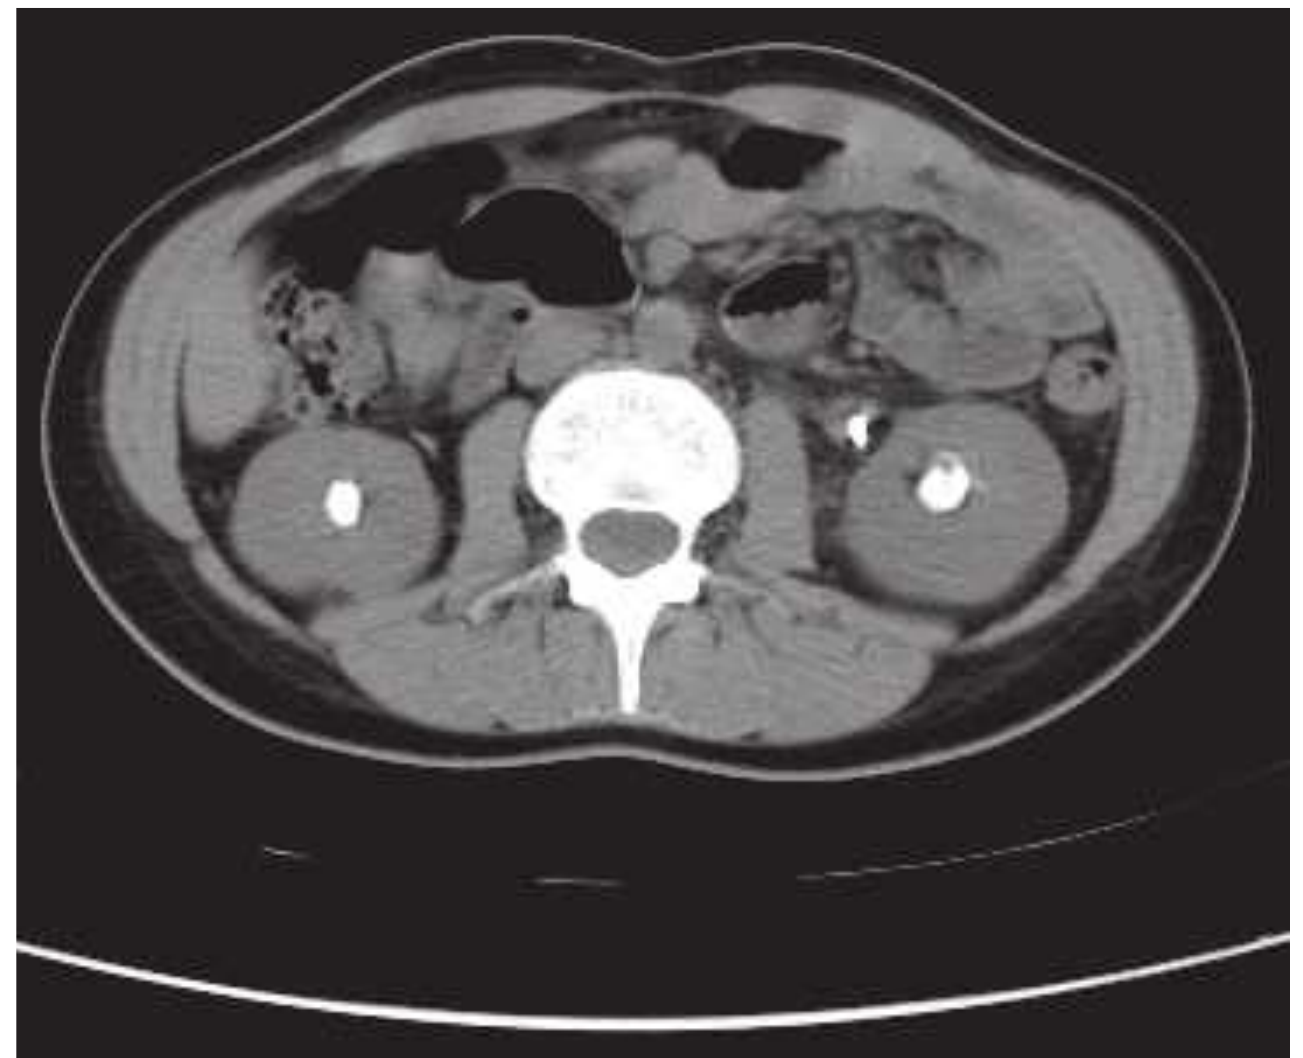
An axial computed tomography image of a known cystine stone former showing bilateral lower pole stones and a stone within the patient's left proximal ureter.
